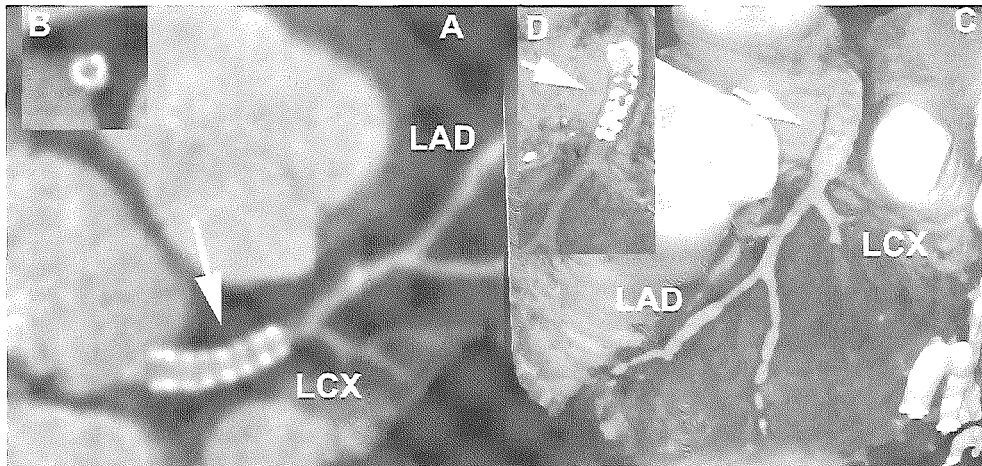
Multislice spiral CT coronary angiogram. The 2D curved multiplanar reconstruction (A) depicts the entire course of the left main and left anterior descending coronary artery (LAD). No neo intimal hyperplasia was noted within the struts of the stent (arrow). Cross section of the stent in the inset (B). The exterior shape of the stent (arrow) can be observed on the volume rendered representation (C) and can be highlighted by altering the settings (D).
